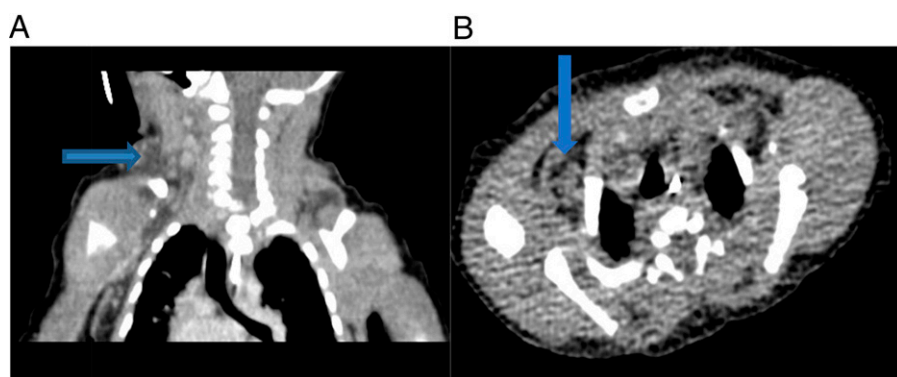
Contrast-enhanced coronal (A) and axial (B) computed tomography scan of the neck shows low attenuation tissue in the lower neck extending to both axillae consistent with fat (arrows). No additional mass was identified.
